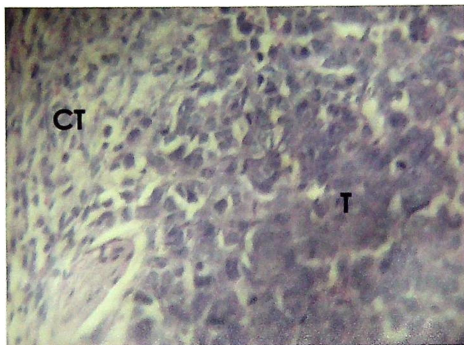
Tumor cell (T) infiltration of the wall of fibrous tissue (CT) in control (untreated) tumor (400X).
